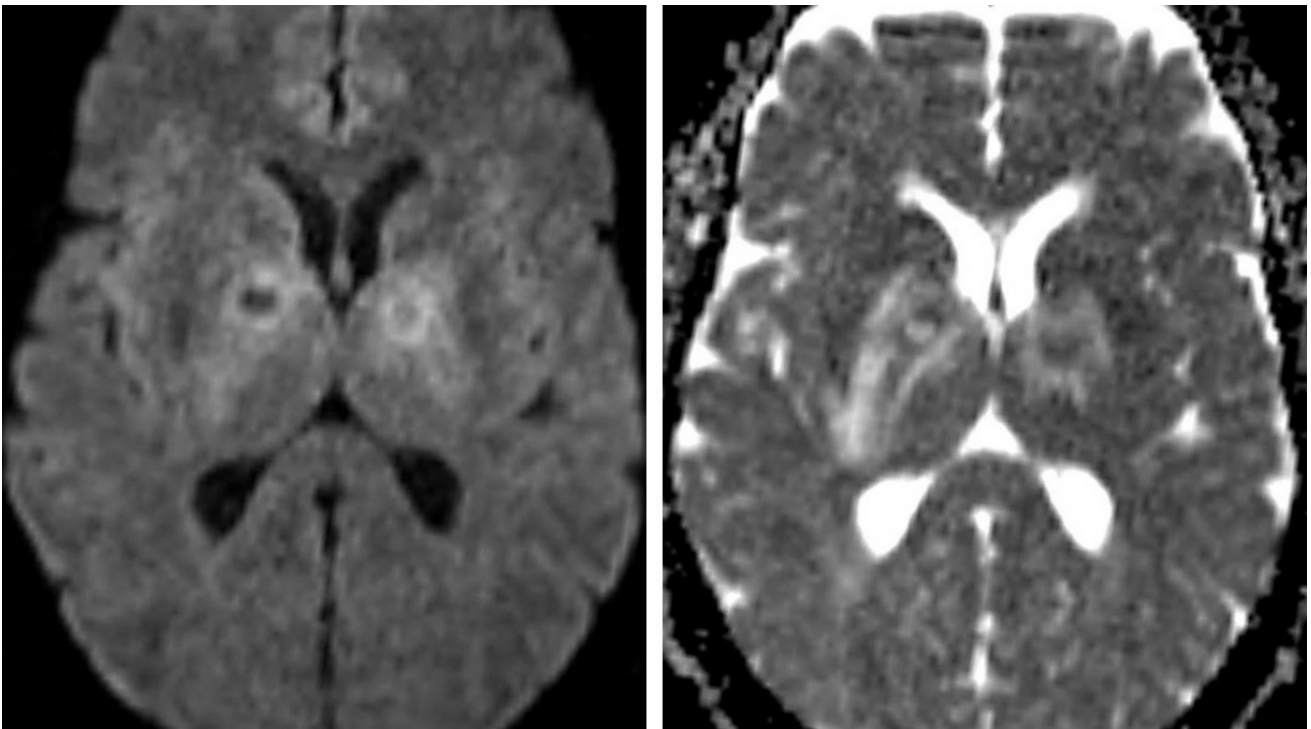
MR DWI/ADC: Restricted diffusion in the rim of the lesion (not centrally as almost always present in pyogenic abscess). Surrounding edema seen as bright perilesional ADC and DWI signal.
